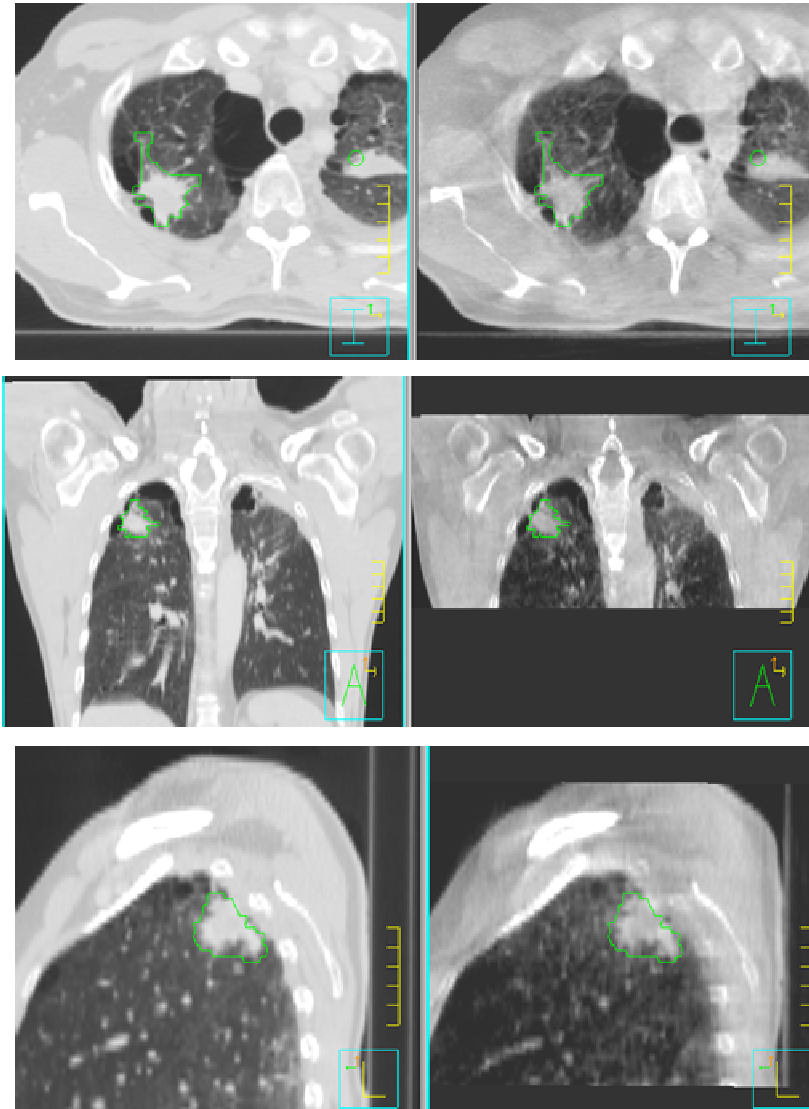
Axial, coronal and sagittal views of a patient treated with HRT to a lesion in the lung delineated in green. 3D/3D registration of the planning CT data set (left) and the CBCT (right) acquired before treatment shows adequate and optimum patient and tumor localization and positioning
